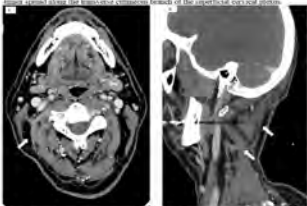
Axial (A) and sagittal (B) contrast-enhanced neck CT for the same 71-year-old female patient presenting with left axillary shoulder girdle and displaced clavicle metastatic structures in situ in the left posterior triangle (arrow), giving rise to three enhancing branches. These findings are consistent with perineural tumor spread along the superficial nerve, involving its three distal branches: the medial, paramedian and lateral supraclavicular nerve.
